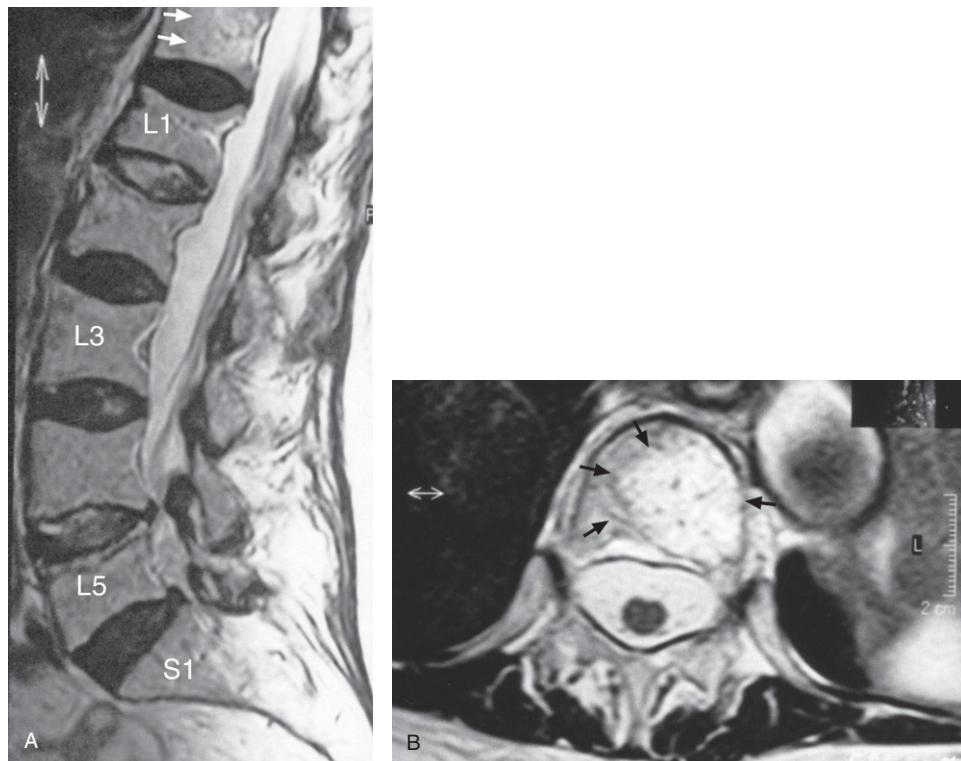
(A) Lumbar MRI sagittal T2-weighted image showing the depression of the L1 superior endplate with lesser depressions of the superior endplate at the L2 and L5 levels with altered marrow signal intensity consistent with acute osteoporotic compression fracture. There is some degree of desiccation of all the lumbar and the 12th thoracic intervertebral discs. There is a normal cord, conus and cauda equina. The white arrows indicate the large benign haemangioma in the T12 vertebral body. (B) MRI axial T2-weighted/TSE* image at the T12 level showing the large benign haemangioma (arrows) in the vertebral body with no pedicle abnormality and no pathological marrow infiltrates.
